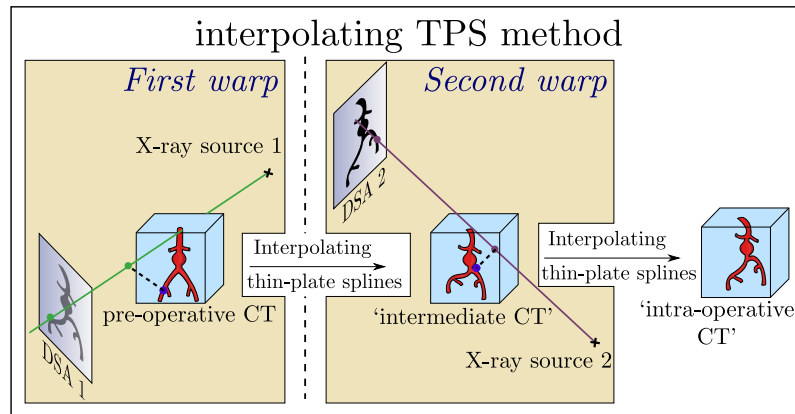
Interpolating Thin-Plate Splines: (left) 3D points are picked on the aorta surface and corresponding 2D target points are picked on the first view (DSA 1). 3D target points are computed as the closest points to the 3D source points on the back-projection lines joining the X-ray source and the 2D target points. A first warp of the aorta surface is produced by registering the aorta surface using interpolating thin-plate splines with the 3D source points and the 3D target points. The updated aorta surface is registered to the second DSA image using the same method as described above. This second warp of the aorta yields the registered aorta surface.
